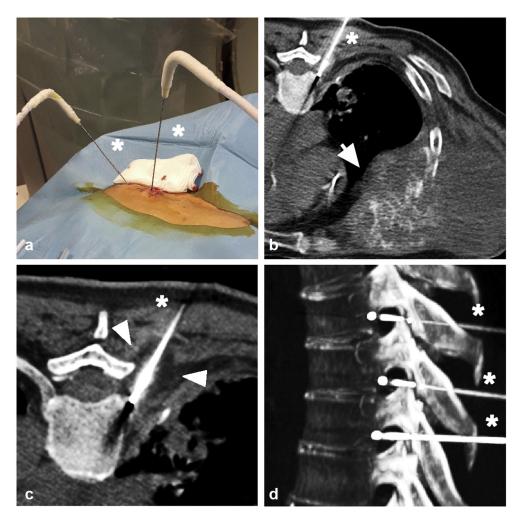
Cryoneurolysis procedure. A patient with a thoracic sarcoma suffering from a left thoracic neuropathic pain had a first CNL from T4 to T7 with excellent results (VAS from 10 to 1). Three months later, the pain recurred on metameric levels T8, T9, and T10, correlated to disease progression. He underwent a second CNL for these 3 levels. (a) Photo of the first procedure, patient in prone position with cryoablation probes (*) positioned under CT guidance. (b) Axial CT image showing the thoracic sarcoma (white arrow), and 1 of the cryoablation probes (*) positioned under CT guidance close to the intervertebral foramina and the chest nerve root. (c) Repeated CT imaging during the freezing cycle to monitor the growth of the ice ball (white arrowheads). (d) CT with volume rendering technique reconstructions during the second procedure, showing the cryoablation probes positioning (*), with 1 needle for each treated level.
